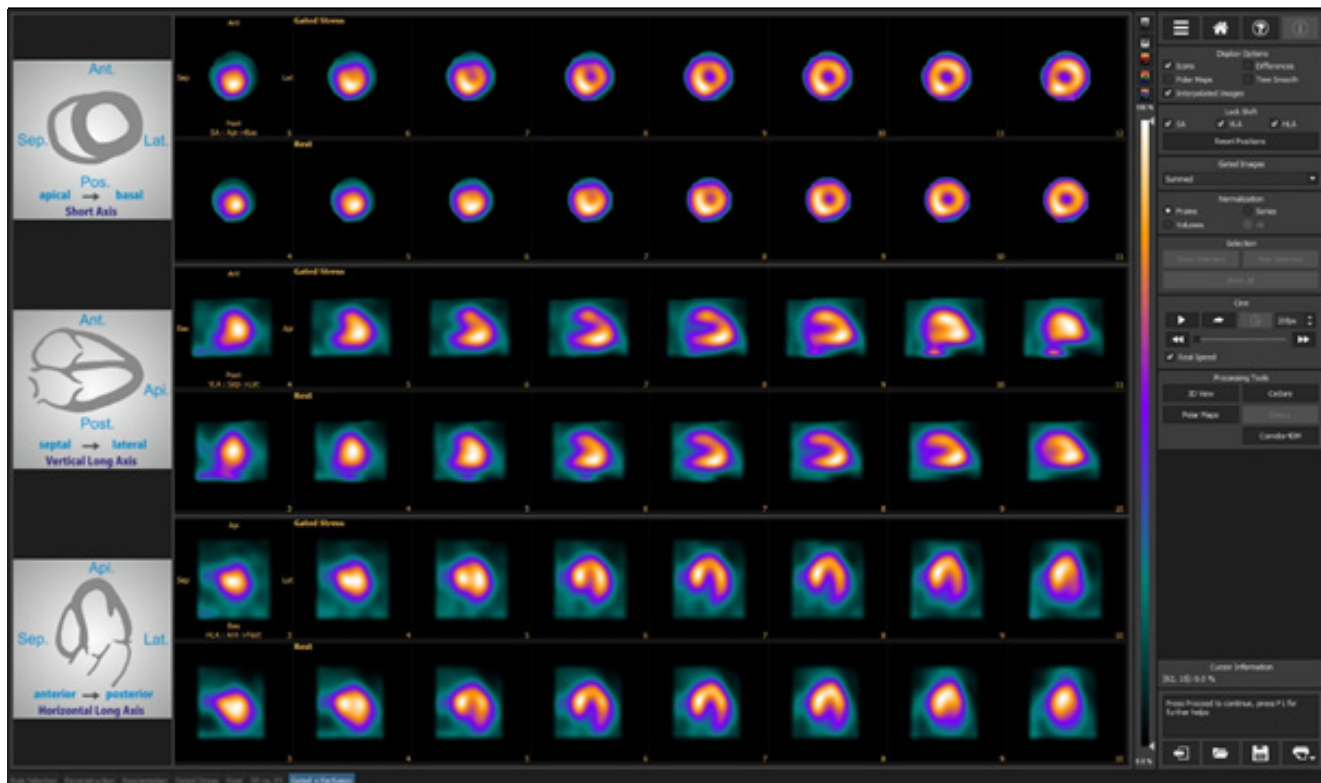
Sections of left ventricular walls in myocardial perfusion scintigraphy.
